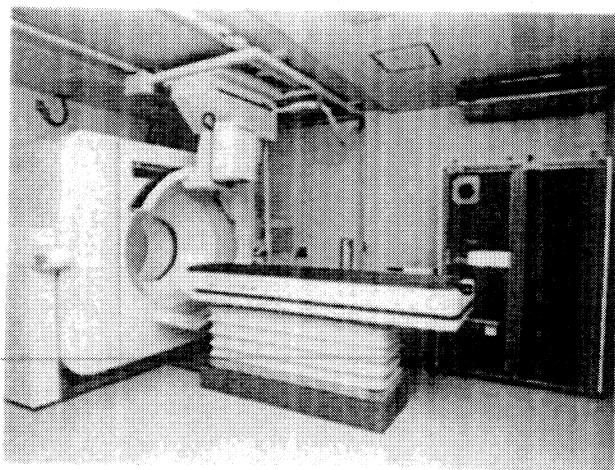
(a) The CT and Laser beam projecting components in our scanning room (left). (b) The overview of our control room with a CT operator console, a multi-image display console, and the treatment planning console (right).
